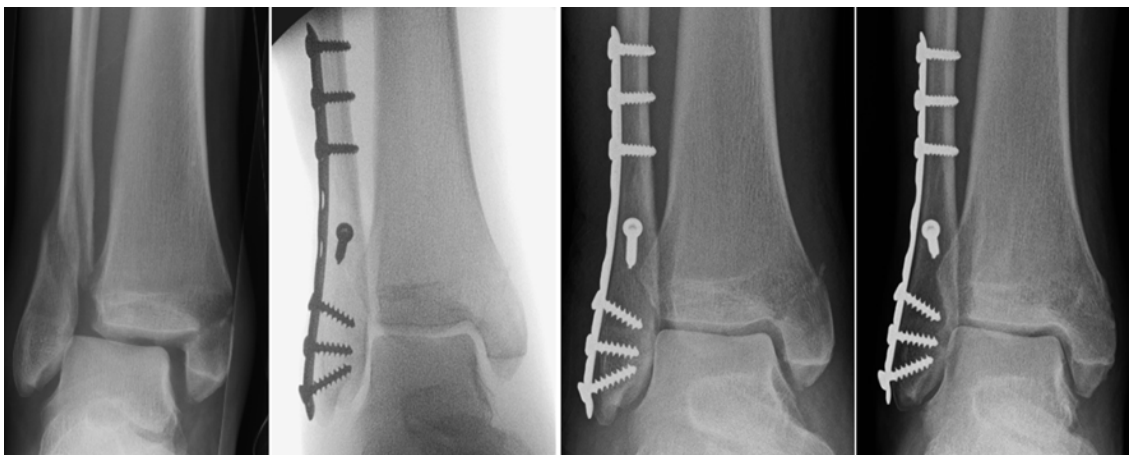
AP radiographs from a 53-year-old patient who was randomised to non-fixation following an anatomical intra-operative reduction and progressed to satisfactory radiographic union.
